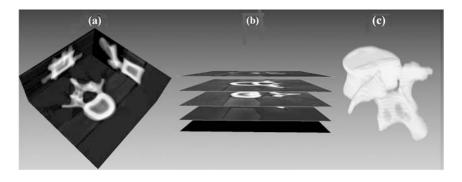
Different visual representations of a CT scan of a vertebra.
